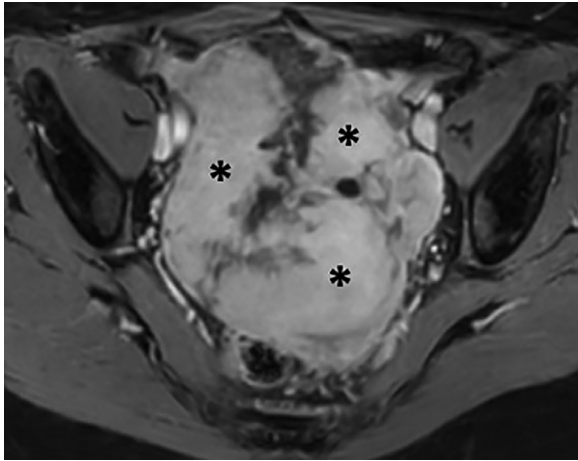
Axial dynamic contrast-enhanced T1-weighted image showing enhancement of the solid components (*).
